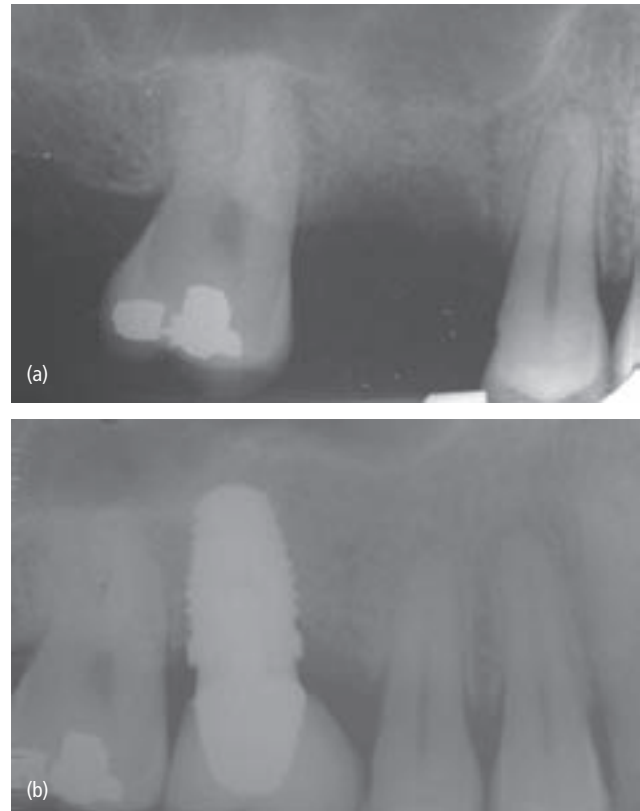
(a) Preclinical view of maxillary right first molar site which was to receive an implant with simultaneous bone-added osteotome sinus floor elevation. (b) A tapered implant had been placed and the radiograph was taken at the fourth year postloading. Platform switching was performed to maintain crestal bone height.
